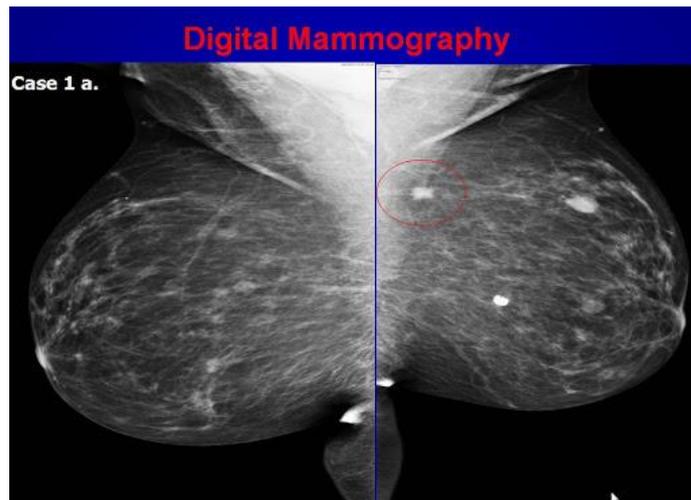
A digital mammogram is a radiographic examination showing the morphology of the anatomical elements of the breast tissue and any pathological lesions it may present. Today, three decades after the initial implementation of mammography continues to be the method of choice.
